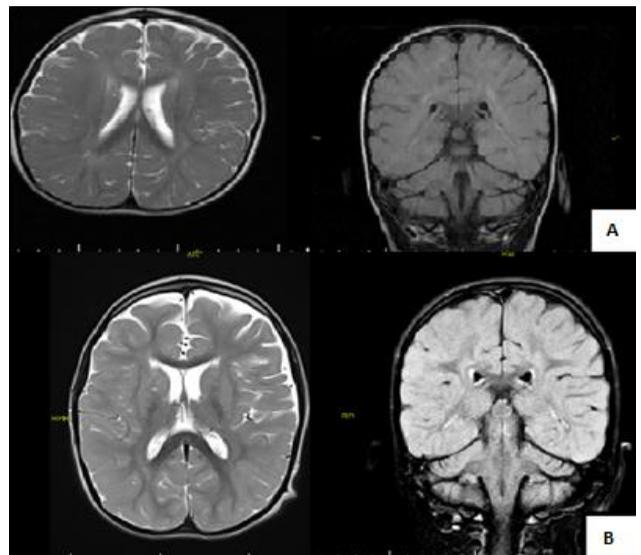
The features of MRI at different ages. 1A. Demyelination, pineal cyst at 4 years of age. 1B. Cerebral atrophy, pineal cyst at 7 years of age.
